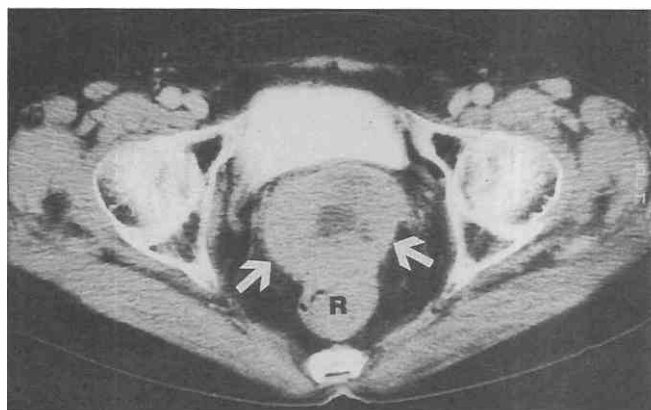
Rectal leiomyosarcoma. CT scan shows a heterogeneous mass (arrows) of rectal (R) origin growing exophytically and displacing the vagina anteriorly. (From Lee SH, Ha HK, Byun JY, et al: Radiological features of leiomyomatous tumors of the colon and rectum. *J Comput Assist Tomogr* 24:407-412, 2000.)
